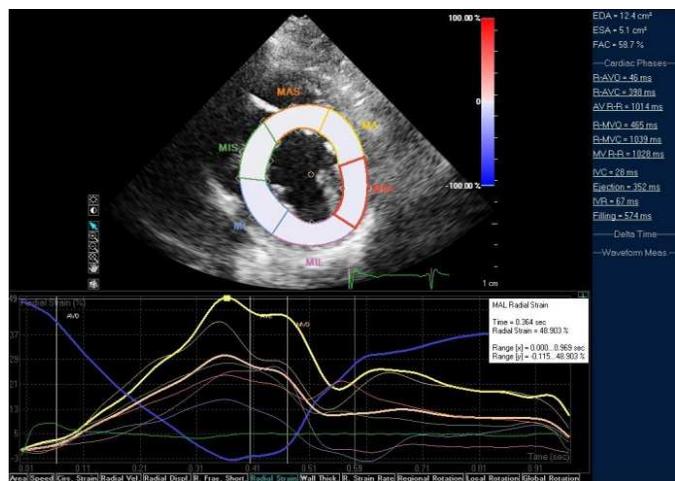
2D-speckle tracking analysis of regional and global radial strain from parasternal short axis view at the level of papillary muscles.
